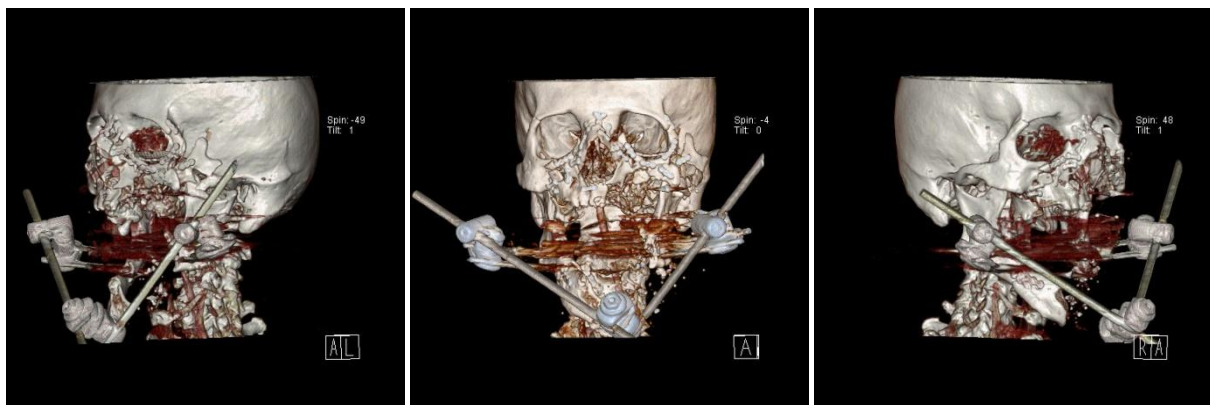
Three-dimensional computed tomography (CT) reconstruction of the skull and viscerocranium (preoperative). Left-anterior (left), anterior-posterior (middle), and right-anterior (right) views. An elderly male (71 years), attempted suicide with a shotgun and was transferred after initial wound care for further reconstruction. The mandible exhibits bone loss in the symphysis/parasymphysis (central unit), bilateral body, and left ramus/angle. Temporary repositioning of mandible fragments was achieved using external fixation in another institution. The maxilla shows defects in the alveolar ridge and hard palate together with multifragmented zygomatic bone on the left.*
